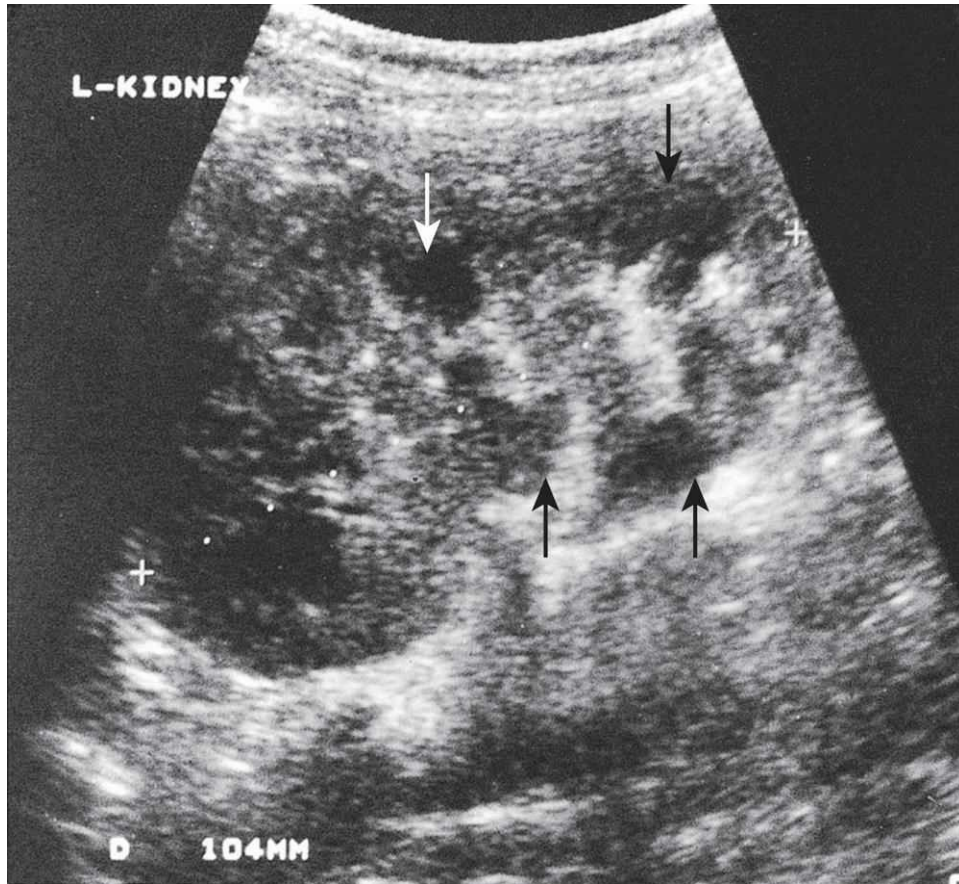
Renal ultrasonogram of an asymptomatic person with tuberous sclerosis showing abnormal echogenicity attributed to presumed angiomyolipomata (arrows).
